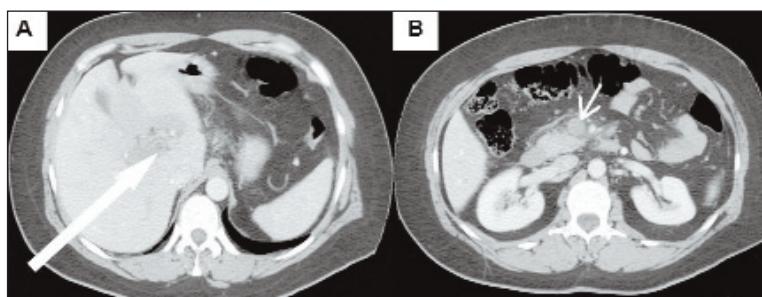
An abdominal CT scan revealed a thrombosed portal vein (long arrow) (A) and a thrombosed SMV (short arrow) (B).
